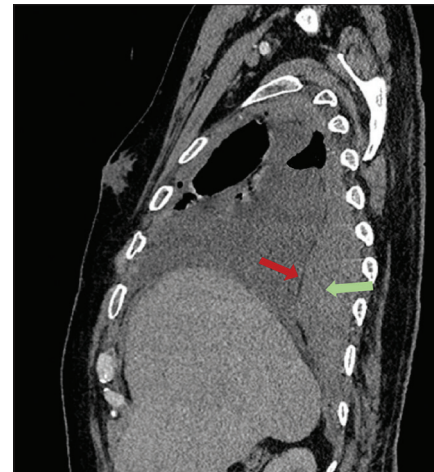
Sagittal computed tomography image showing an extrapleural hematoma (green arrow) displacing the extrapleural fat (red arrow) anteriorly
